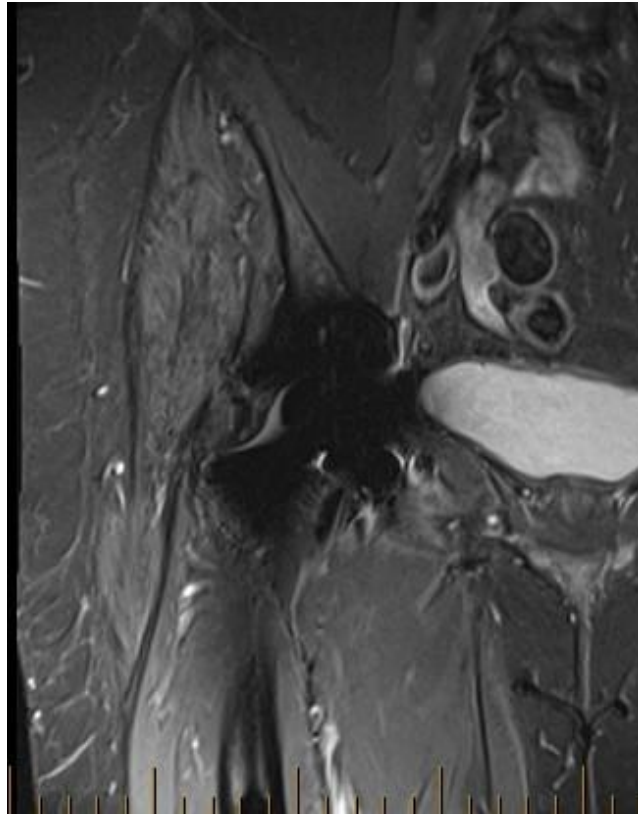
MRI hip 2018 post-operative
